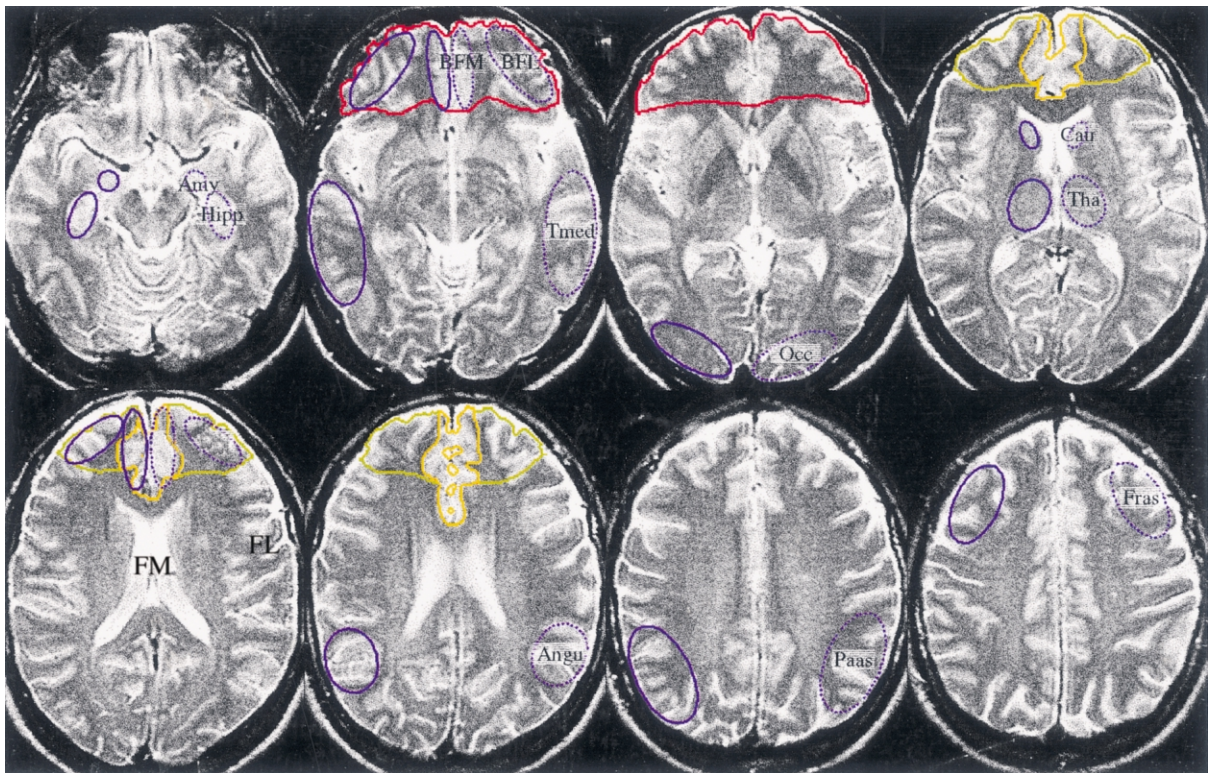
MRI scans showing the anatomical placement of ROIs. The basal frontal cortex is outlined in red, the medial frontal cortex in yellow, the lateral frontal cortex in green, and the 13 paired ROIs of the cerebrum in blue. The pair of cerebellar ROIs is not included in the picture.
